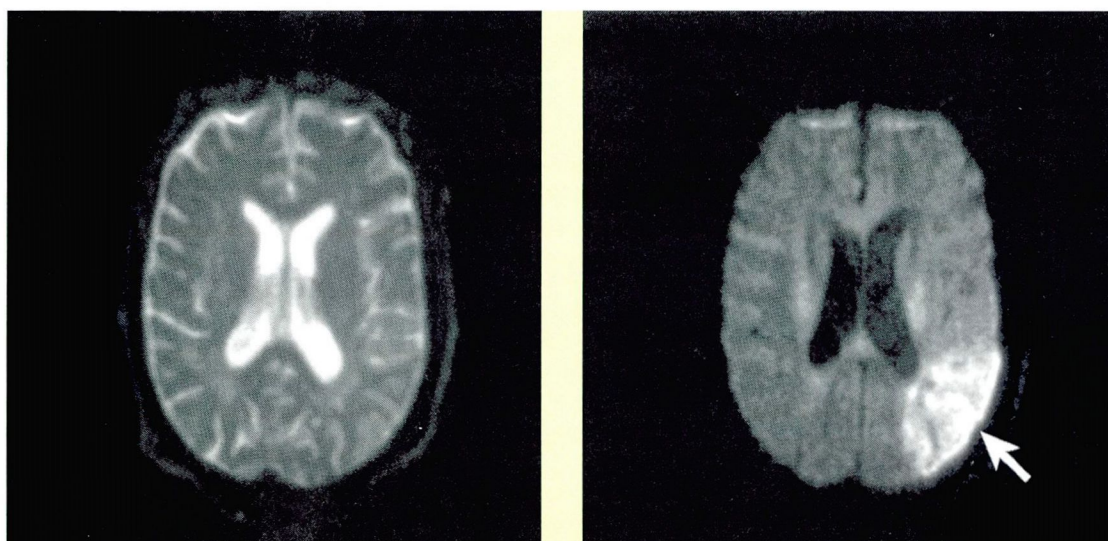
Left, a standard T2 magnetic resonance imaging scan appears normal in this patient 4 hours after the onset of stroke symptoms. Right, a diffusion-weighted MRI scan in the same patient reveals the area of ischemia (arrow).
